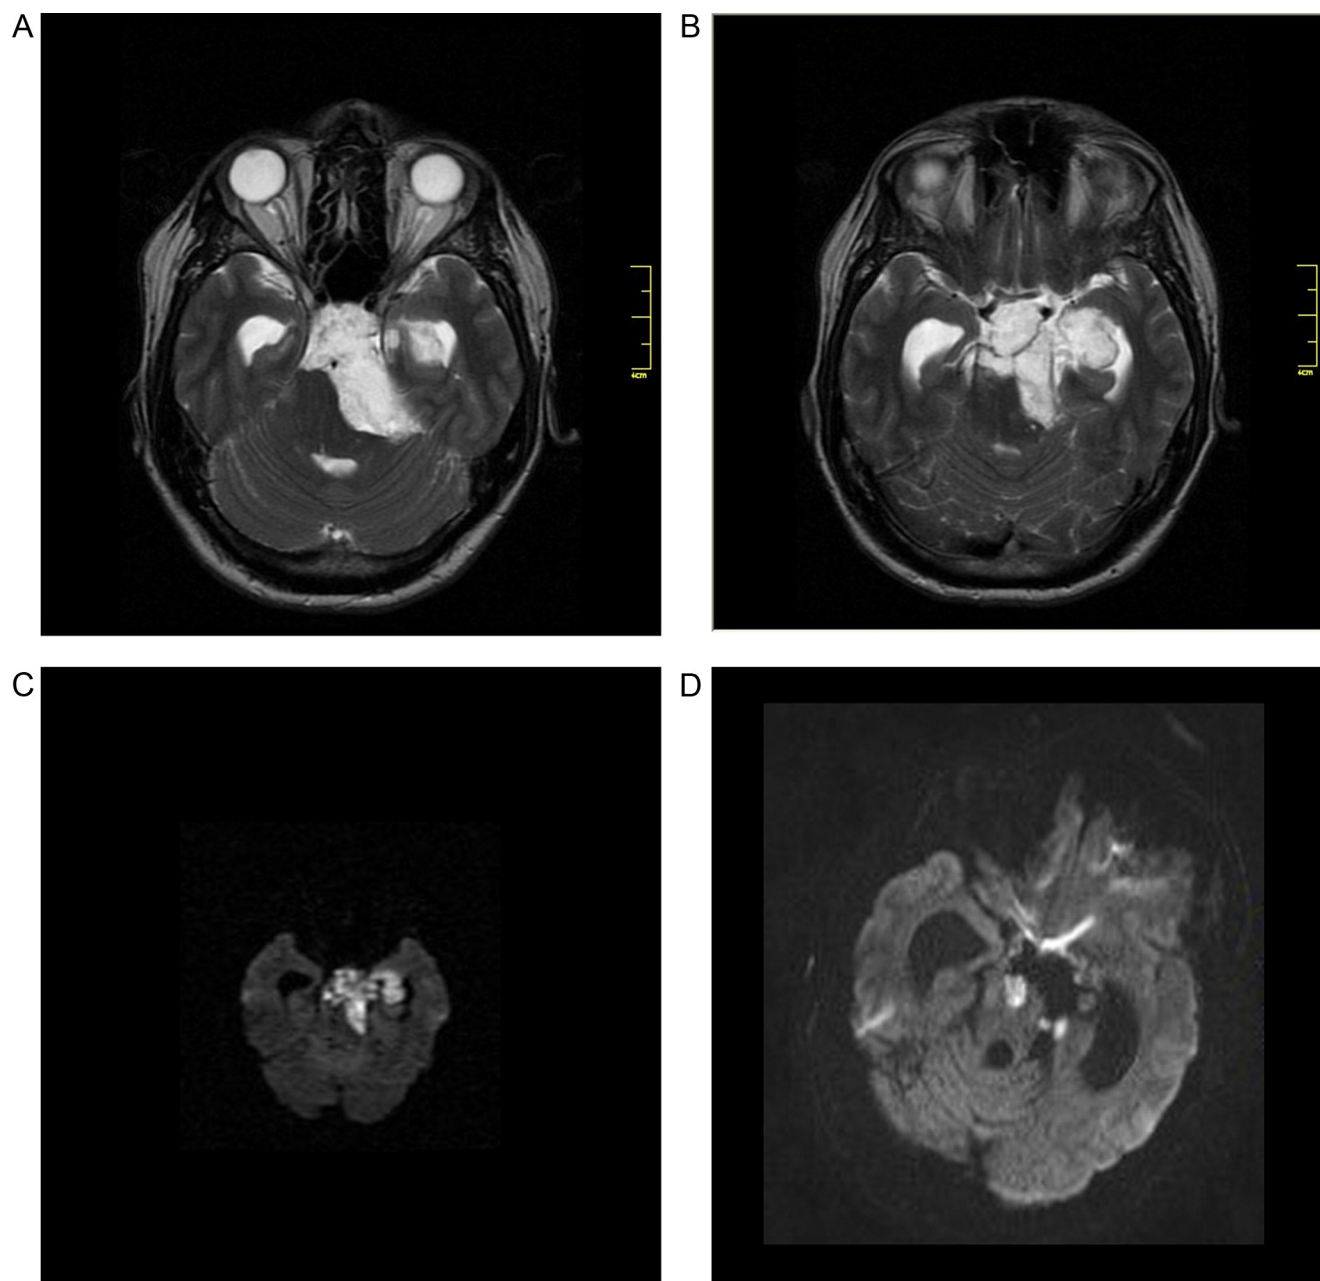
Preoperative MR examination in T2-weighted images (A,B) and DWI sequence (C) revealing epidermoid cyst located in the left cerebellopontine angle and extending supratentorially. Last follow-up MR obtained after incomplete tumor removal shows stable tumor remnants in DWI sequence (D).
